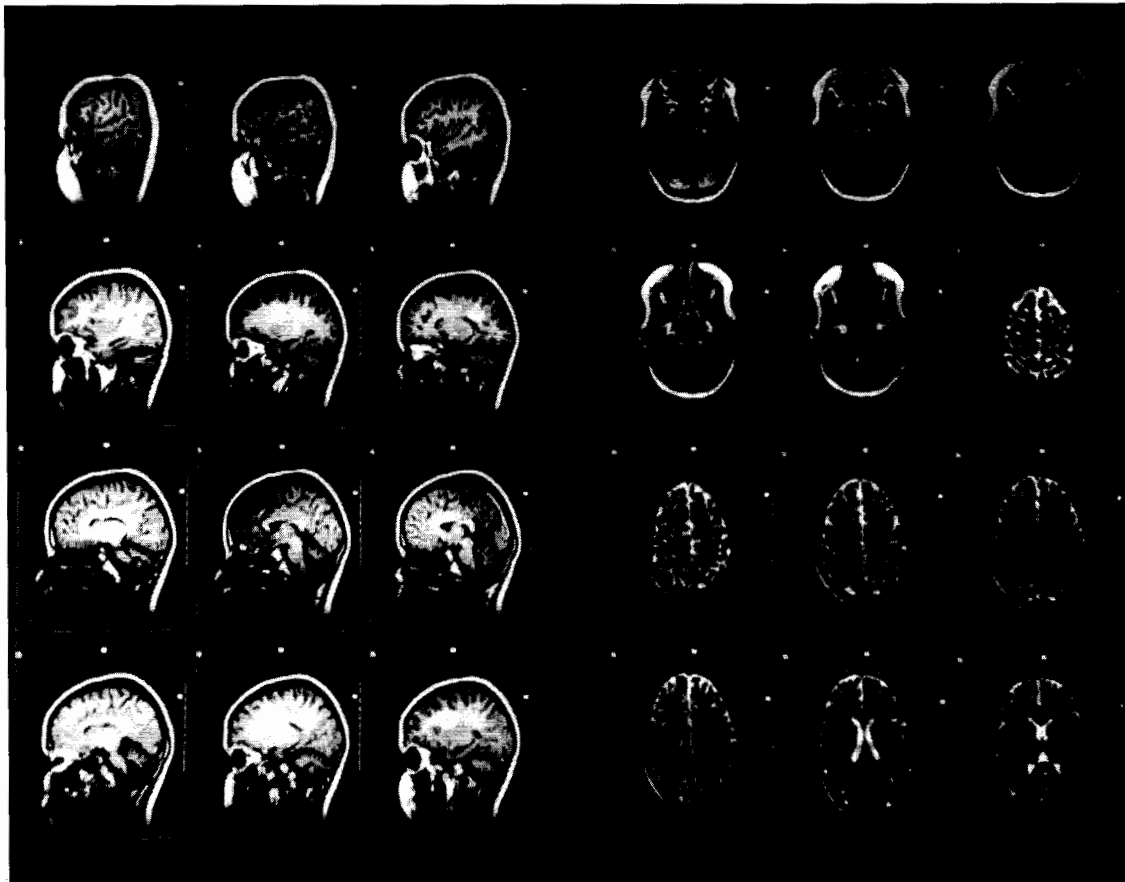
Magnetic resonance images.
